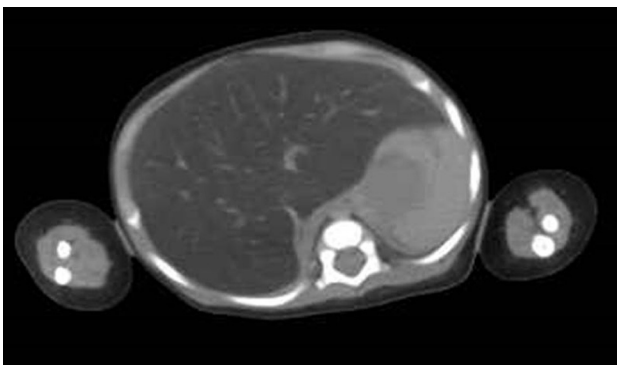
Postmortem CT imaging of the abdomen. Postmortem CT of the entire body was performed before autopsy. All scans were performed using a four-slice CT scanner (Asteion/TSX-021B/4A, Toshiba, Tokyo, Japan) with a slice thickness of 1 mm and settings of 120 kV and 225 mAs for the head and 120 kV and 100 mAs for the body. These CT images were interpreted by radiologists. Postmortem CT demonstrated lower absorbance in the whole liver, suggesting fatty attenuation.
